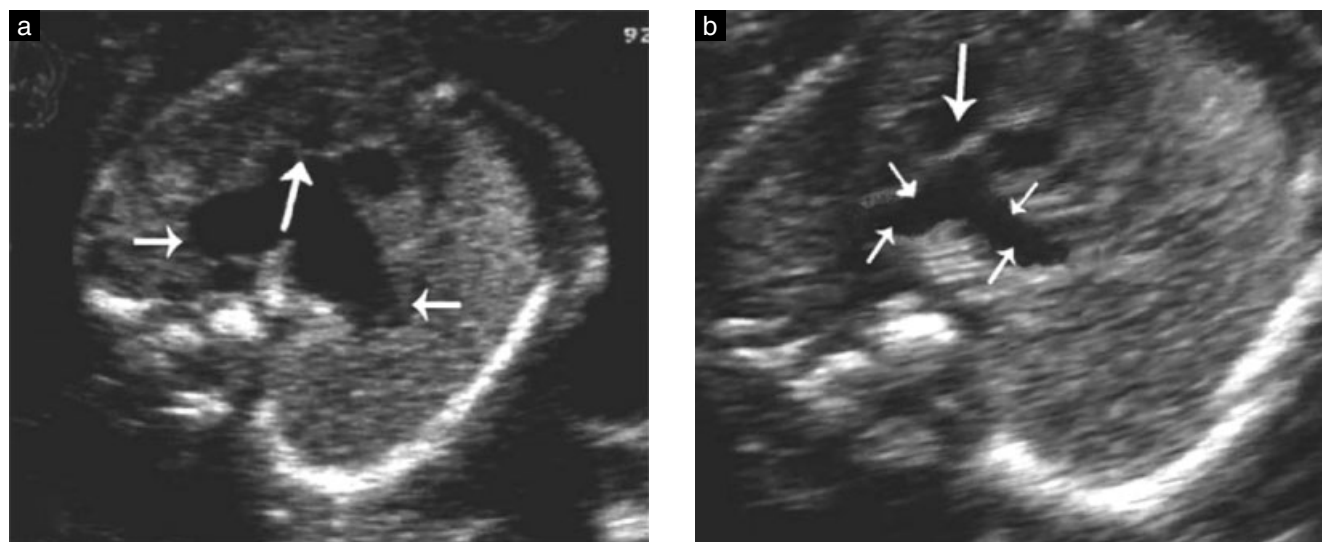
Ultrasound images of the right ventricular outflow tract showing dysplastic valve leaflets (big arrows), and different degrees of dilatation of the main and branch pulmonary arteries. The branch pulmonary arteries were severely dilated (small arrows) in most (15/18) cases of variants of absent pulmonary valve syndrome (APVS) with tetralogy of Fallot (a); a lower degree of the branch pulmonary arteries dilatation was present in the remaining cases, including the three cases of APVS-intact ventricular septum variants (b).
